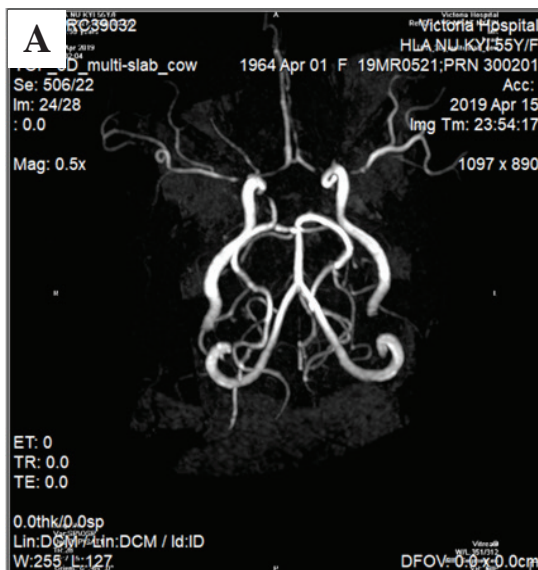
A. MRA (brain) of the patient. B. CTA (brain) of the patient showing segmental narrowing on both sides beyond terminal internal carotid artery (ICA)
